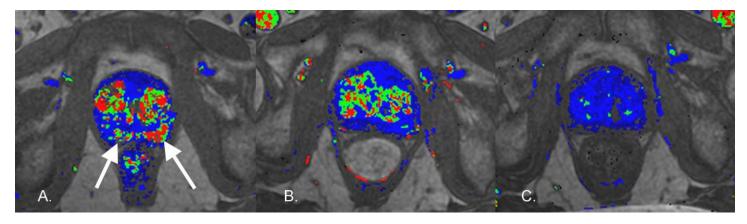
73 year old man with a Gleason 6 prostate cancer. The pre-CyberKnife DCE parametric map (A) shows bilateral peripheral zone tumor (arrows) (K^{trans} 3.24 1/min, K_{ep} 9.45 1/min, EVF 0.62). Follow-up MRI 6 months after radiation treatment (B) shows resolving peripheral zone tumors (K^{trans} 0.78 1/min, K_{ep} 0.58 1/min, EVF 0.82). Follow-up MRI 12 months after CyberKnife SBRT (C) shows complete resolution of peripheral zone tumors (K^{trans} 0.21 1/min, K_{ep} 0.571/min, EVF 0.62).
